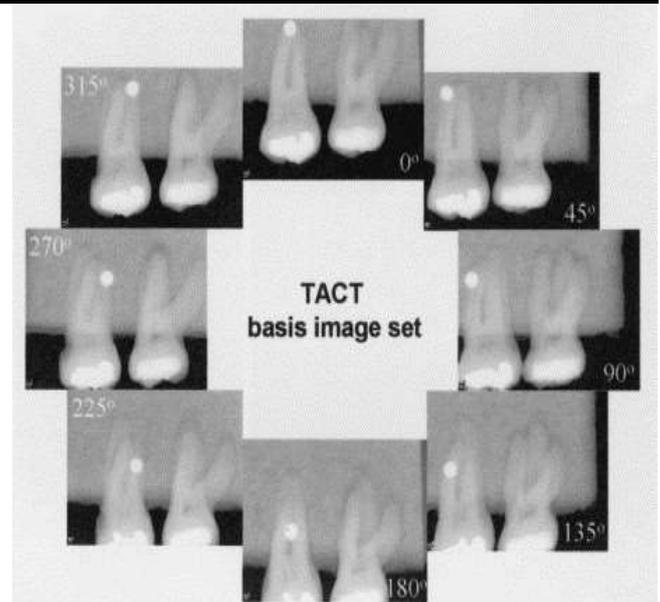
shows the imaging section for teeth by using the Tuned Aperture Computed Tomography (TACT) technique (Daniel J et, al. 2003).
